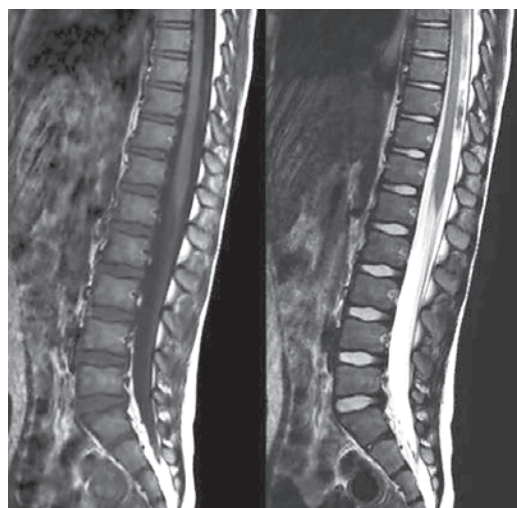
T1 plain and T2 Lumbosacral spine MRI in GBS
